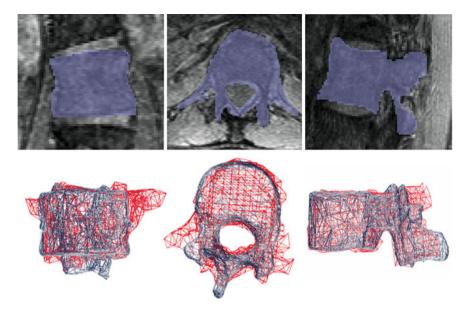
Corresponding segmented cuts from MRI scans, along with 3D polygonal mesh superimposed with 3D reconstructions obtained from the proposed method
